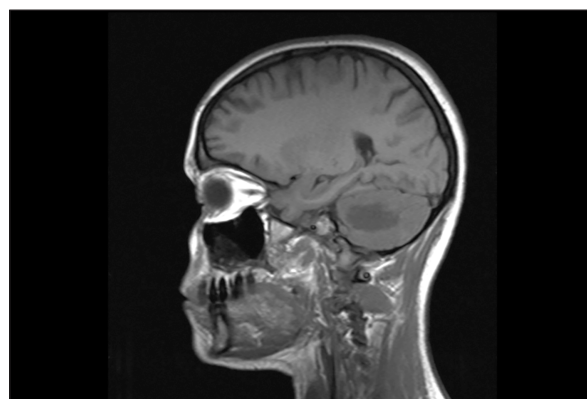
b. Brain MRI – sagittal section – hypointense T1-weighted lesion located in the cerebellar hemisphere
